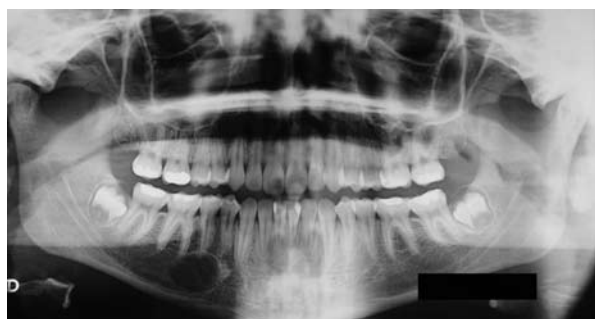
Panoramic X-ray view. Traumatic bone cyst located in the region of the right lower second premolar.
